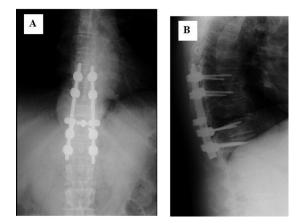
(A). Postoperative anterior-posterior radiograph of the spine. (B). Postoperative lateral radiograph of the spine.
